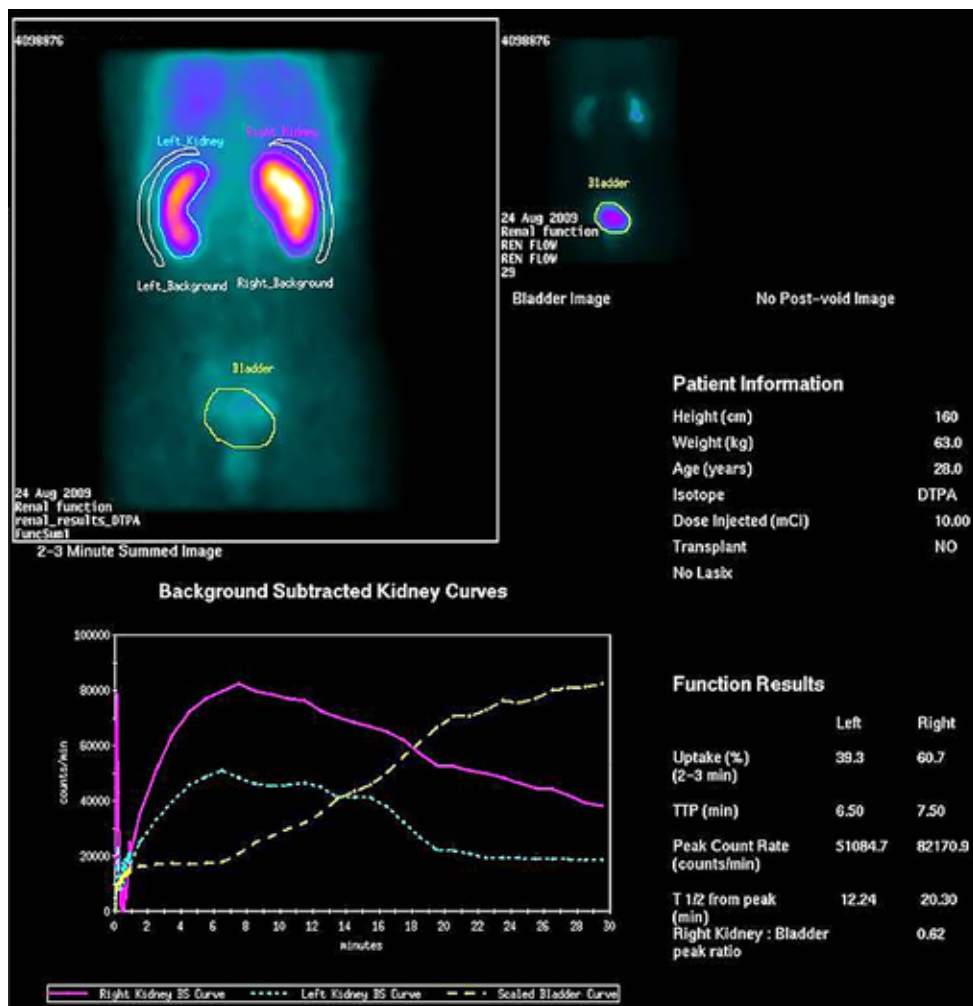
Pre-procedure (renal angioplasty) renal Tc 99-m DTPA scintigraphy with captopril test. Left kidney function (39%) was decreased compared to the right kidney (61%).
